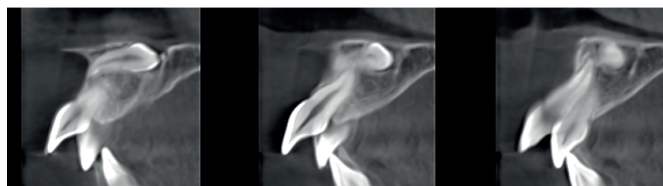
Representative CBCT images of ST-related malposition of maxillary incisor teeth.
